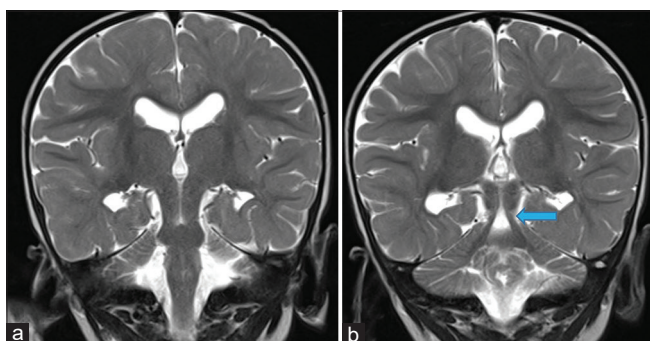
(a and b) MRI brain T2W coronal images showing “molar tooth” appearance of the elongated superior cerebellar peduncles running laterally (arrows) and the dorsal band crossing the midline and likely joining the middle cerebellar peduncles. MRI = magnetic resonance imaging, T2W = T2 weighted
